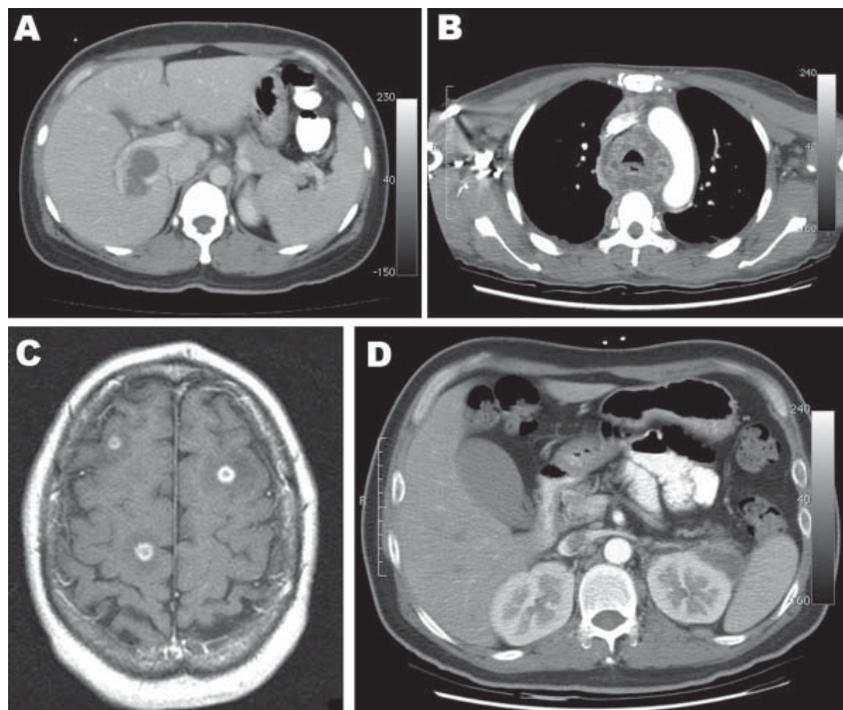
A) Computed tomography (CT) scan of the abdomen showing a liver abscess adjacent to the portal vein. B) CT scan of the chest at the level of the aortic arch showing mediastinum abscesses surrounding the trachea. C) Brain magnetic resonance imaging (T1 weighted, spin echo, with contrast) showing multiple intracerebral abscesses (smooth ring-enhancing lesions with surrounding vasogenic edema). D) CT scan of the abdomen of patient from panel C, showing a left perinephric abscess and thrombus.
